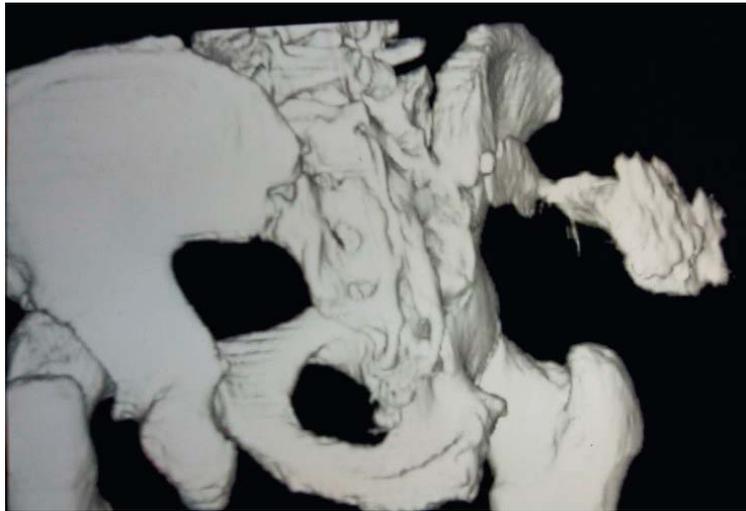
On a contrast-enhanced computed tomography, contrast liquid in the fistula spreads to the joint
